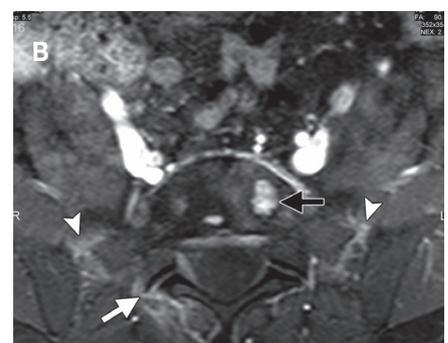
Capsulitis and enthesitis in ankylosing spondylitis. Coronal oblique (a) and axial oblique (b) contrast-enhanced fat-suppressed T1-w MR images show enhancement of both anterior capsules (arrowheads) consistent with anterior capsulitis; enhancement of the ligamentous portion of both sacroiliac joints (arrows in a), consistent with enthesitis, along with enhancement of the right facet joint (white arrow in b); and endplate erosions (black arrow in b).
